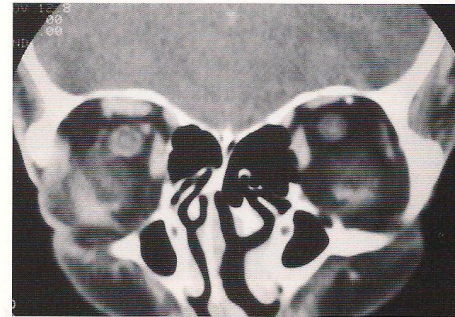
Coronal computed tomography showing the same lesion depicted in Fig. 5-27.
